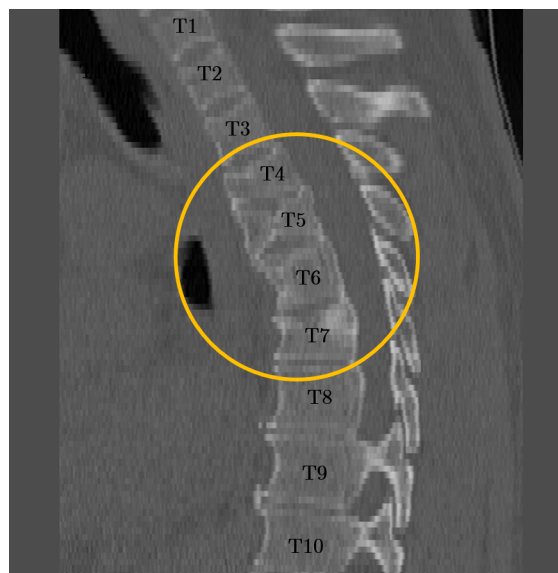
Sagittal view of the patient's CT examination where the fracture of T5-T7 vertebrae can be observed.
